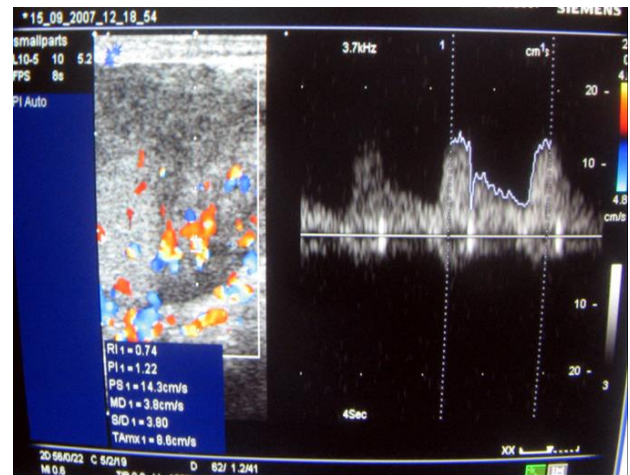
Colour Doppler increased intranodular blood flow. Pulse Doppler shows RI-0.74, PSV-14.3 cm/sec.
